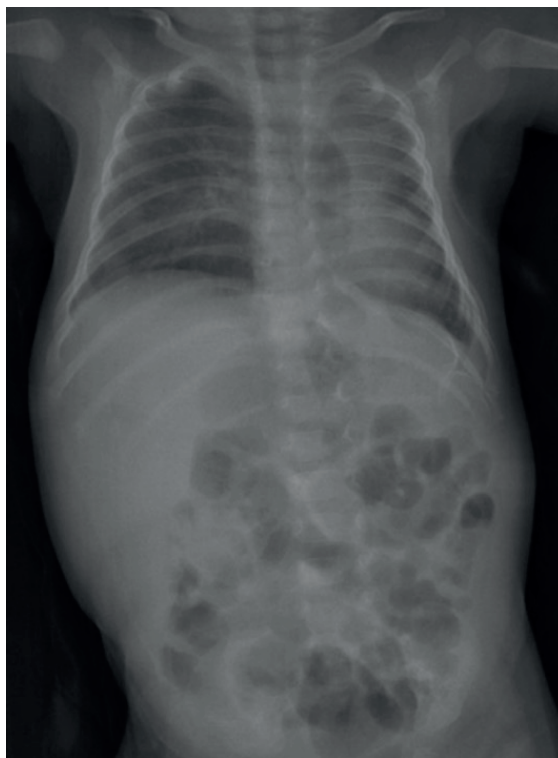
The patient's radiographic imaging after ten days of the initial mesenchymal stromal cell treatment. The ventilation of both the left and right lung has improved. The appearance of the intestinal loops is normal.
